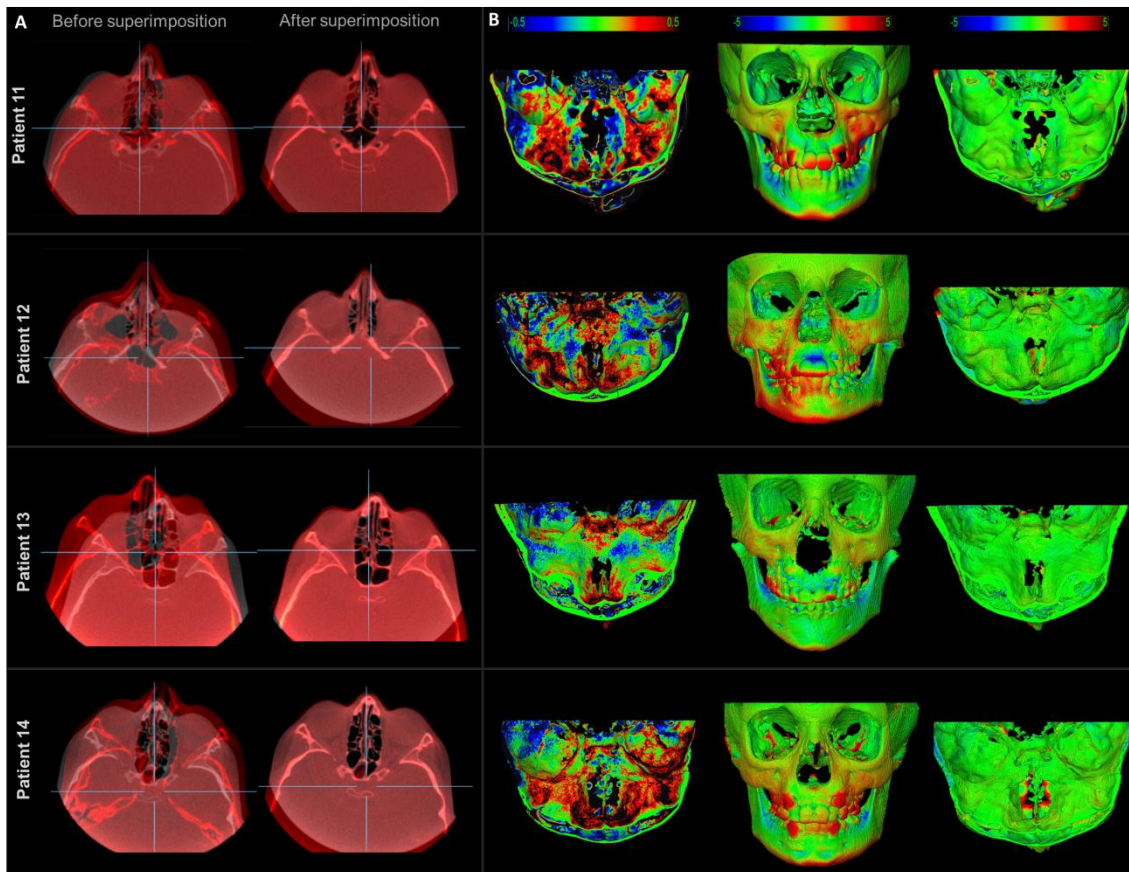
CBCT superimposition of growing patients subjected to RME with 1-year follow-up. (A) axial slices view before and after anterior cranial base superimposition in Ondemand3D. (B) 3D models after superimposition showing 3D displacements via color maps. In the 0.5mm color map, the black areas represent changes of 0.5 mm, blue/red areas represent changes less than 0.5mm and green areas represents no changes. The 5mm color map, the areas in black, red and blue are due to the RME and normal growth. The changes at the cranial base were minimal as shown in green color (CMF application software).
